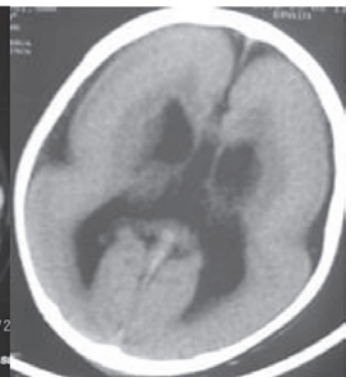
Plain CT brain showing smooth surface of brain with shallow sylvian fissure - figure of 8 appearance in Lissencephaly
